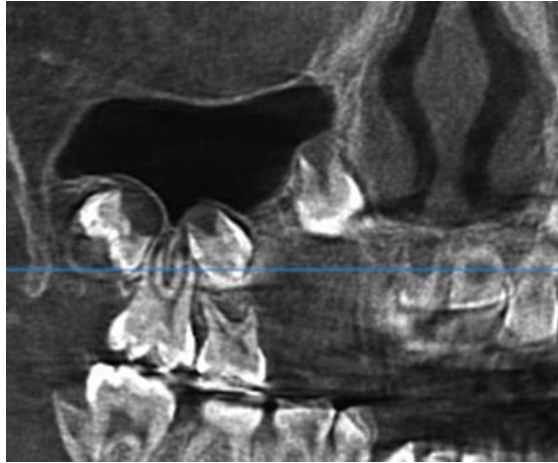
A CBCT image showing a large, well-defined mixed lesion
